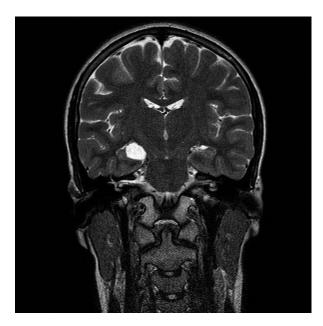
T2-weighted MRI image revealing the presence of an arachnoid cyst at the medial side of the right temporal lobe with a pressure effect on the hippocampus.
